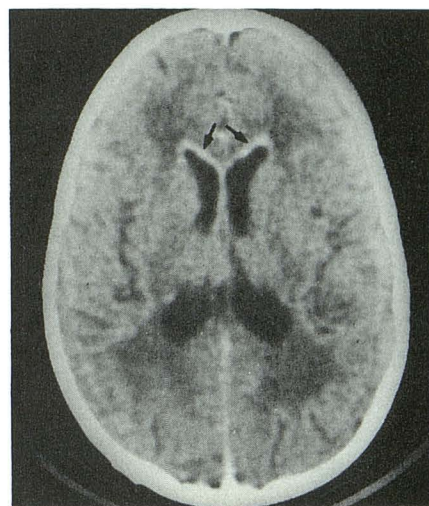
Postcontrast CT scan shows ependymal enhancement at frontal horns of lateral ventricles (arrows). Also note periventricular lucencies with mild ventricular dilatation.
